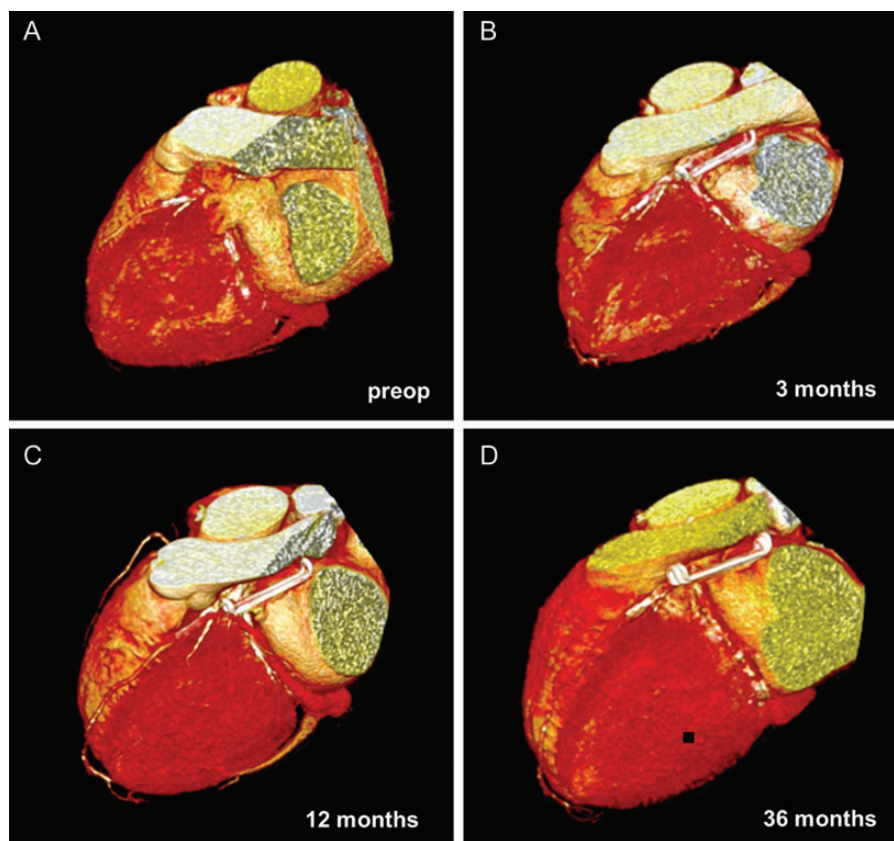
In vivo* monitoring of clip safety and stability using serial computed tomography (CT). CT image series of an exemplary patient before (A), at 3 months (B), 12 months (C) and at 36 months (D) after implantation indicating a stable clip position and durable left atrial appendage occlusion early postoperatively as well as throughout the entire follow-up period.
